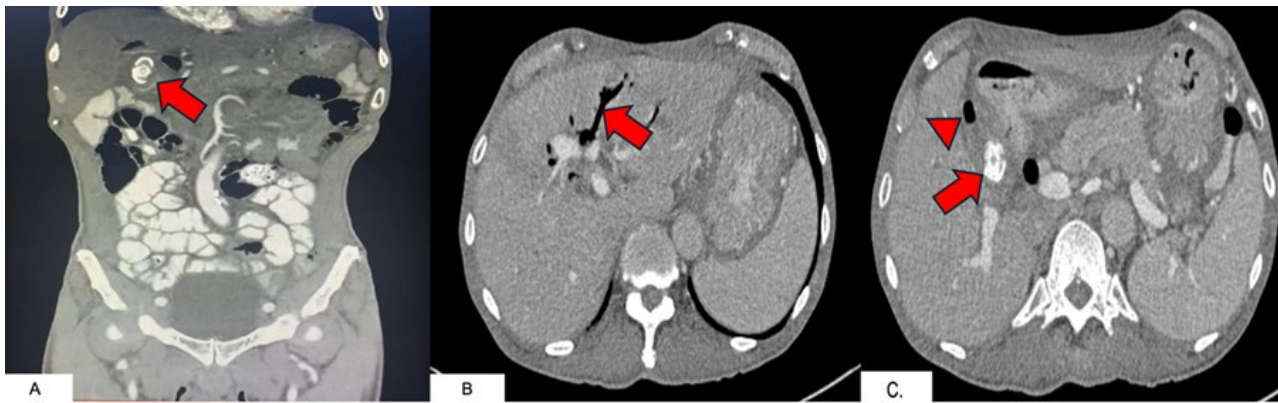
Contrast enhanced CT scan of the whole abdomen. (A) Lamellated cholelithiasis 1.9 x 1.7 cm in the gallbladder (B) Axial view at the superior hepatic level with the arrow pointing to the presence of pneumobilia (C) Axial view of the inferior liver at the gallbladder fossa level with the gallbladder walls thickened and indistinct. The arrowhead points to a pocket of air within the gallbladder fundus. The arrow indicates the lamellated cholelithiasis presumably at the gallbladder body. Loss of the normal intervening fat plane between the gallbladder and duodenum.
